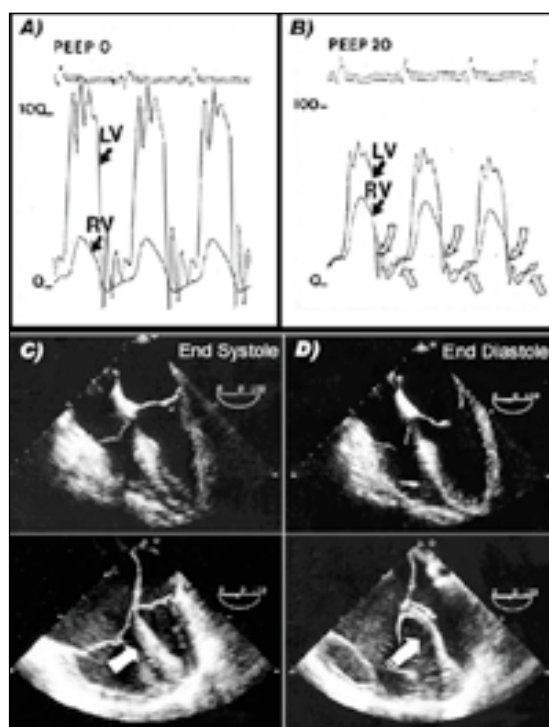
Acute Cor Pulmonale produced by application of an elevated PEEP level during mechanical ventilation of a patient with prior normal RV function (A). Simultaneous Right (RV) and Left (LV) heart catheterization show a subsequent (B) dramatic increase in RV systolic pressure (i.e. PAPs), reduction of systemic arterial pressure, and a longer RV contraction, with end systolic RV pressure exceeding end systolic LV pressure (empty curved arrows, shaded areas). The trans septal gradient is maintained in mesodiastole (RV and LV pressure equalization), but volume overload may produce a further shift of the gradient towards the left (empty straight arrows, shaded areas). Echocardiographic equivalent (TEE 4 chamber view) of this phenomenon in another patient with decompensation of chronic cor pulmonale. Left panels (C) show what happens at end systole in this heart (down) compared to a normal heart (up): septal flattening and leftward shift (septum paradoxus) is evident (arrow), in addition to RV enlargement and Right atriomegaly. The same hearts are shown in right panels (D) at end diastole: further leftward septal shift (arrow) occurs because
